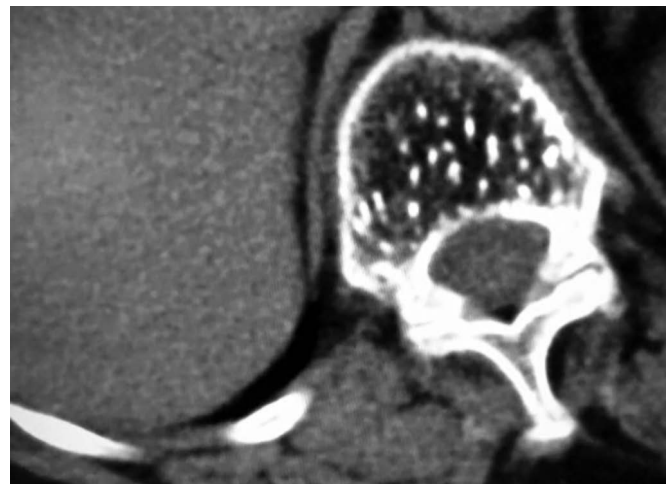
Axial CT scan cut showing the characteristic Polka Dot pattern.
